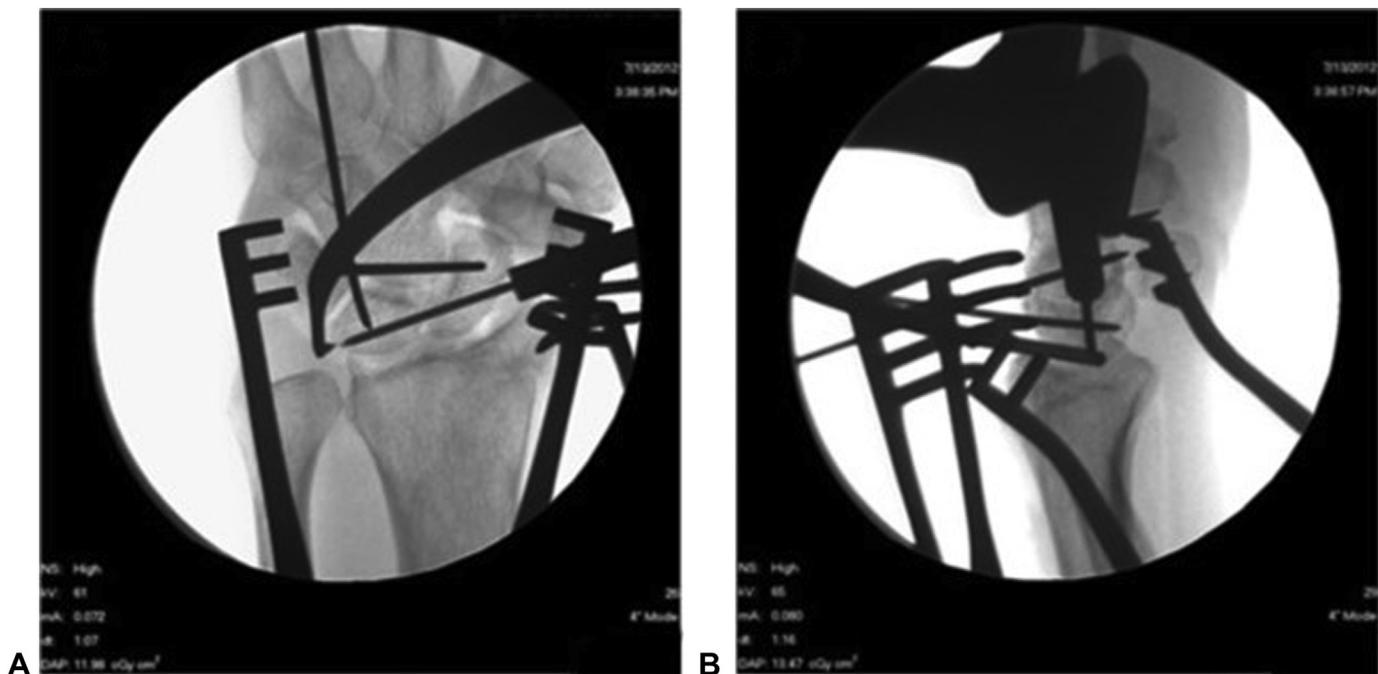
The guidewire is placed along the central axis of the scaphoid and lunate as visualized on the posteroanterior A and lateral B radiographs, respectively, ending at the proximal corner of the lunate A. (From Paci GM, Yao J. Surgical Techniques for the Treatment of Carpal Ligament Injury in the Athlete. Clin Sports Med 2015;34:11-35; with permission).
